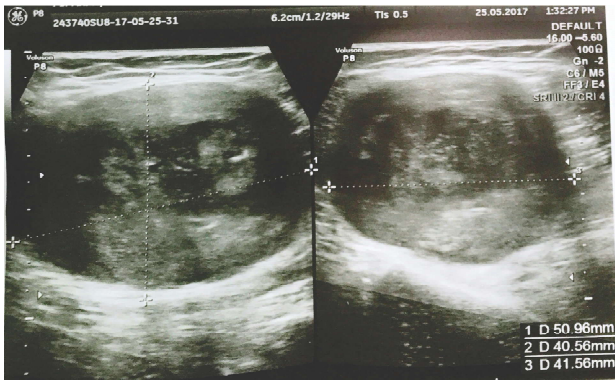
The ultrasound imaging shows a solid well defined heterogeneously hypoechoic space occupying lesion seen in left popliteal fossa.
